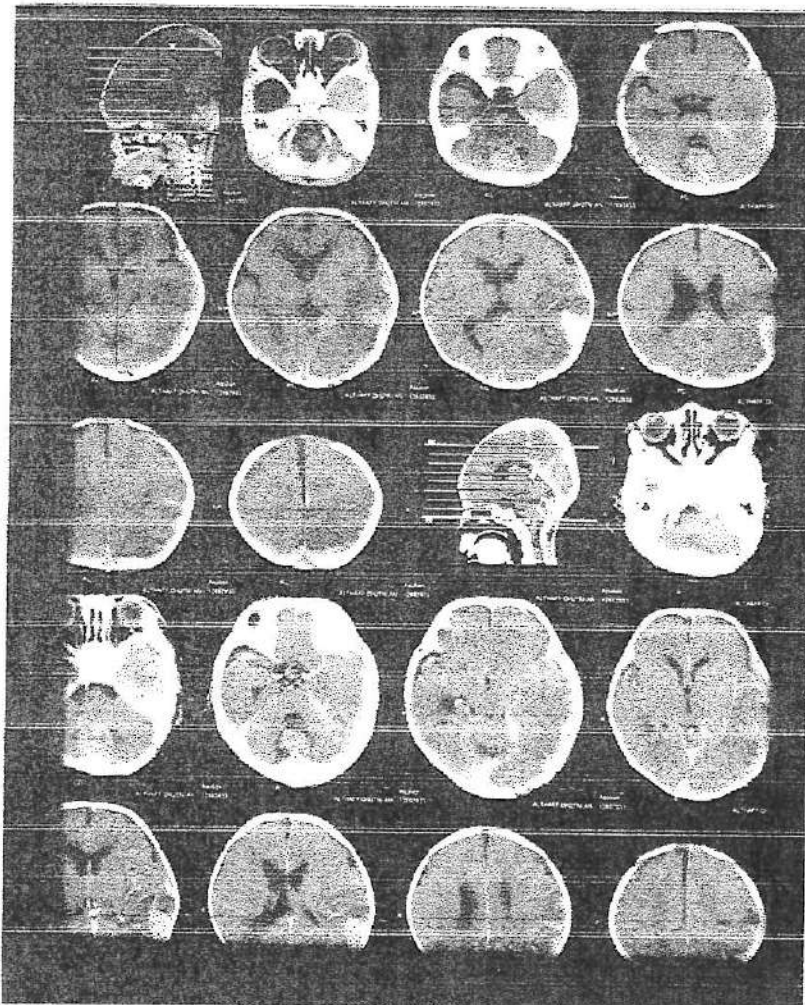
Head CT scan on August 16th 2018 showed ICH and SDH
